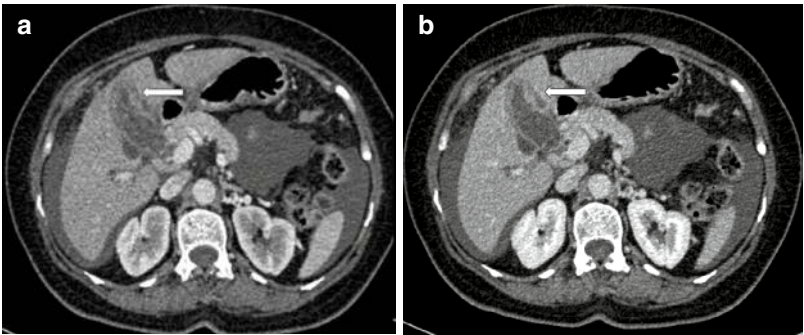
A case of a gallbladder carcinoma: (a) Noncontrast and (b–d) triple-phase contrast-enhanced CT showing enhancing asymmetric mural thickening in the fundus and body region with a single-layer enhancement pattern (white arrow)
